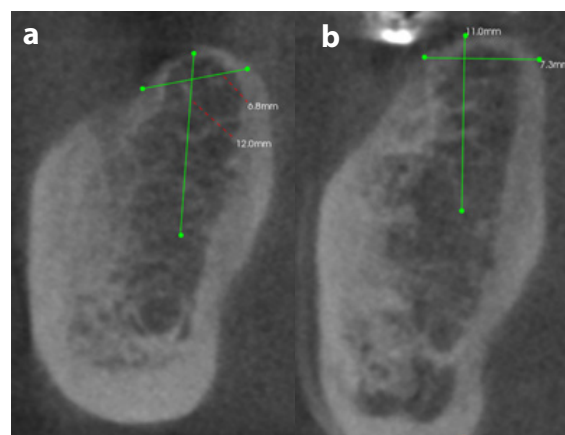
Cone Beam CT scan of bone dimension a) 46 site b) 36 site
